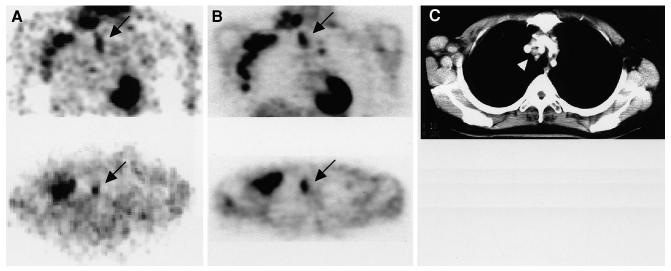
Patient 1. Images obtained by FDG hybrid PET (A) and dedicated PET (B) (top: coronal; bottom: axial) show hot uptake at mediastinal site (arrows). Eight-millimeter lesion is seen on CT (arrowhead) but was diagnosed as negative for NHL because of size criteria.
